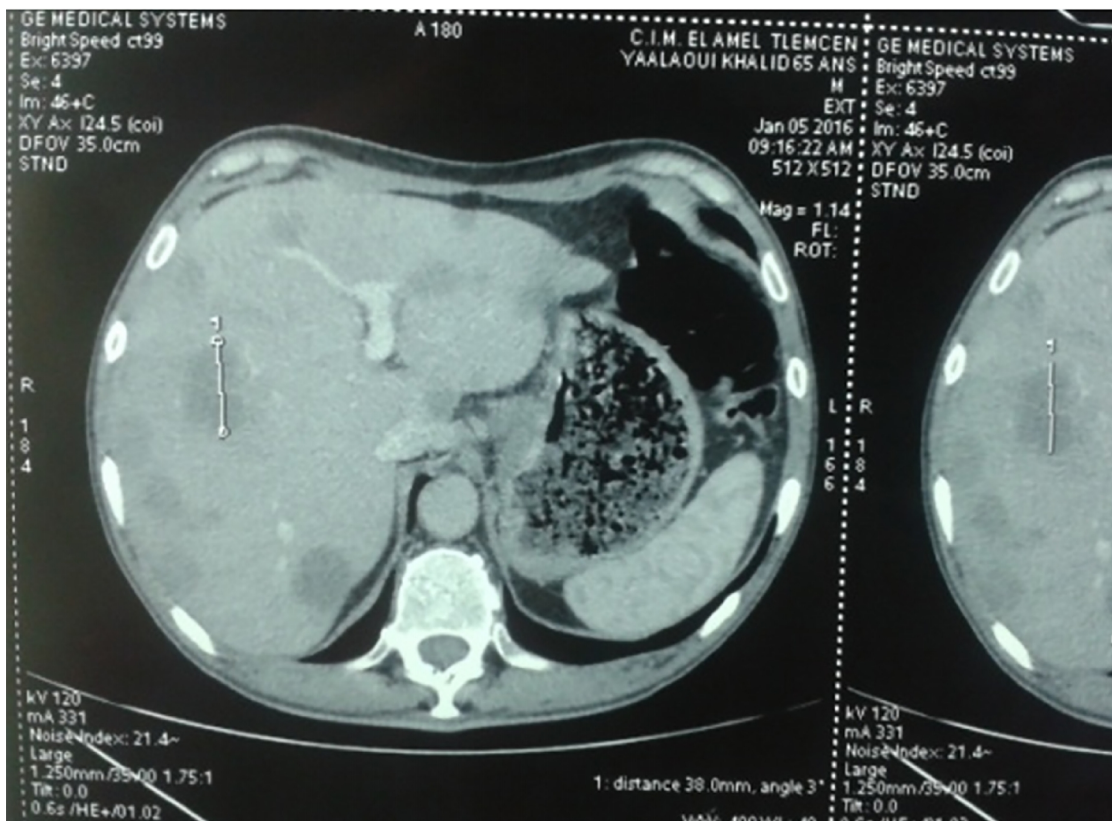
CT scan shows that the metastatic liver nodules were markedly reduced after three cycles of chemotherapy
